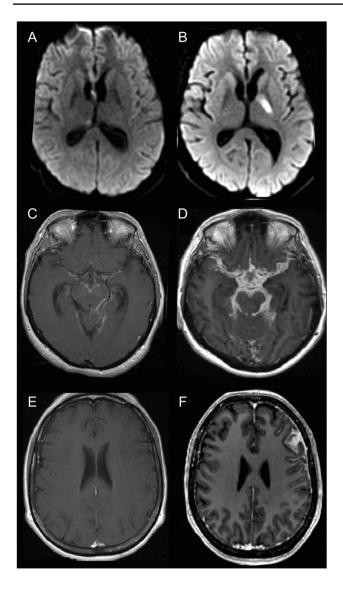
Findings on magnetic resonance imaging (MRI) of the brain among HIV-negative patients with tuberculous meningitis who developed a paradoxical manifestation. Case 2. A normal diffusionweighted imaging (DWI) at baseline, B follow-up imaging 12 weeks after anti-tuberculous treatment initiation revealed an internal capsule infarct. Case 3. C gadolinium-enhanced T1-weighted image (T1WI) showing mild/moderate basal meningeal enhancement at the time of tuberculous meningitis diagnosis, D follow-up MRI 14 weeks after treatment initiation showed severe pachymeningeal enhancement and hydrocephalus. Case 4. E baseline gadolinium-enhanced T1WI shows minimal leptomeningeal enhancement, F follow-up imaging seven weeks after treatment revealed a left frontal tuberculoma
